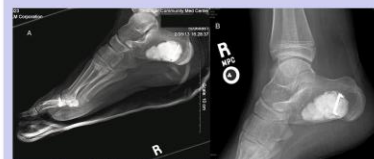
Lateral radiographs: A-immediately post-operative, and B-at nine months post-operative.
